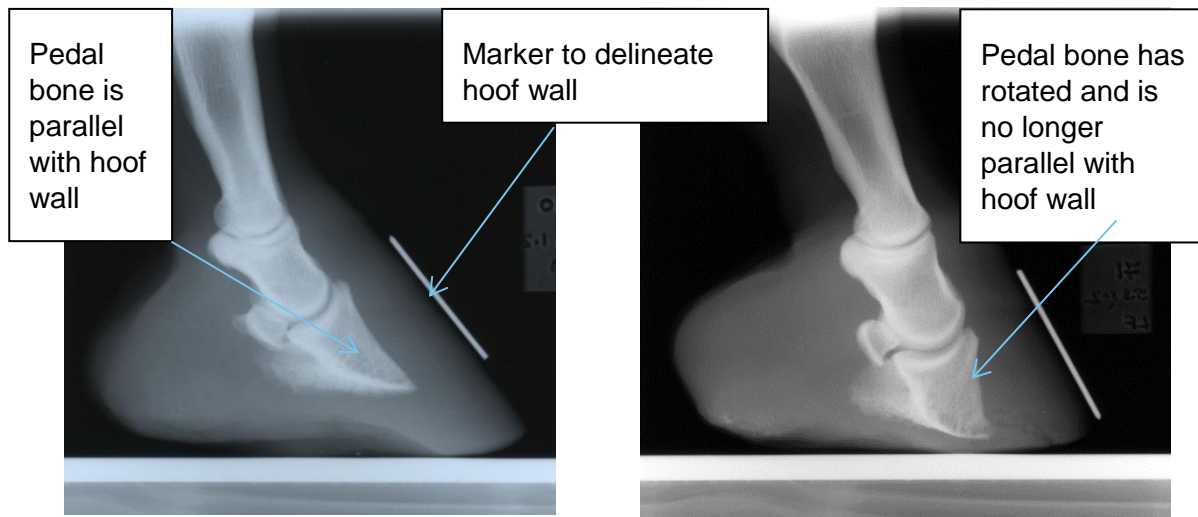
X-ray of a normal donkey foot
